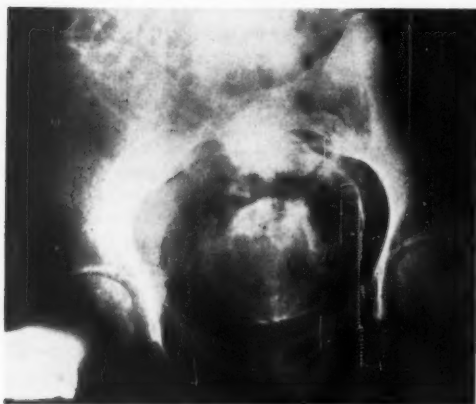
Roentgenogram obtained Sept. 22, 1959. Numerous radiolucent spaces are readily visible in the pelvis. The ring-like soft tissue clouding in the center of the area is due to the dilated cervical lip, which is surrounded by carbon dioxide and air. Pelvic examination demonstrated the cervix to be dilated 5 cm.
